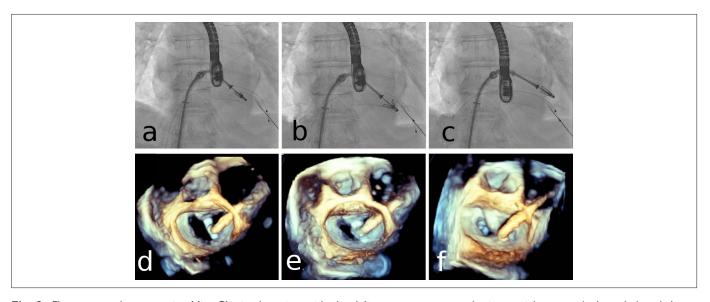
Fluoroscopy demonstrating MitraClip implantation with clip delivery system across the interatrial septum (a, b, and c) and three-dimensional transesophageal echocardiography of surgeon's view of mitral valve during the procedure (d, e, and f).
